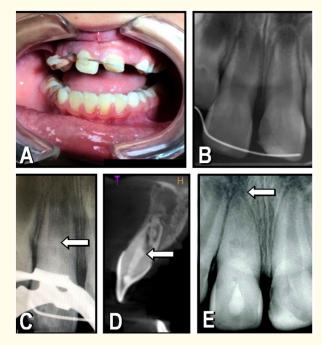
A: Clinical photograph showing the splinted maxillary right central incisor. B: Preoperative radiograph of the right central incisor showing a wide root canal and an open apex. C: Postoperative radiograph showing the placement of the BDT (arrow) after induction of bleeding and blood clot formation. D: Lateral view by cone beam computed tomography demonstrating the level of BDT application (arrow) and wide open apex. E: Follow-up radiograph after 30 months showing closure of the apex (arrow) and thickening of the dentinal walls.
